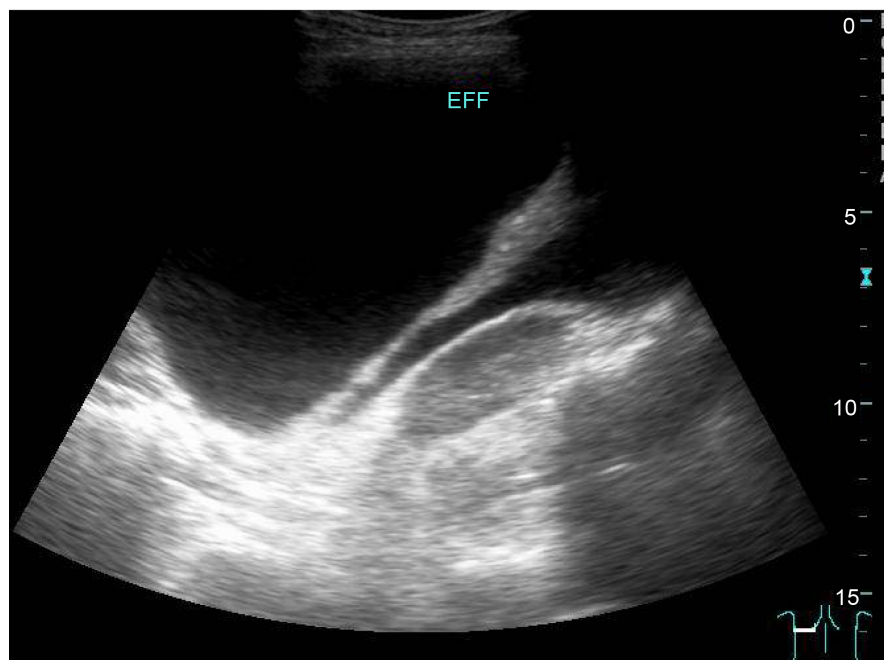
Sonographic appearance of an echo free pleural effusion.
